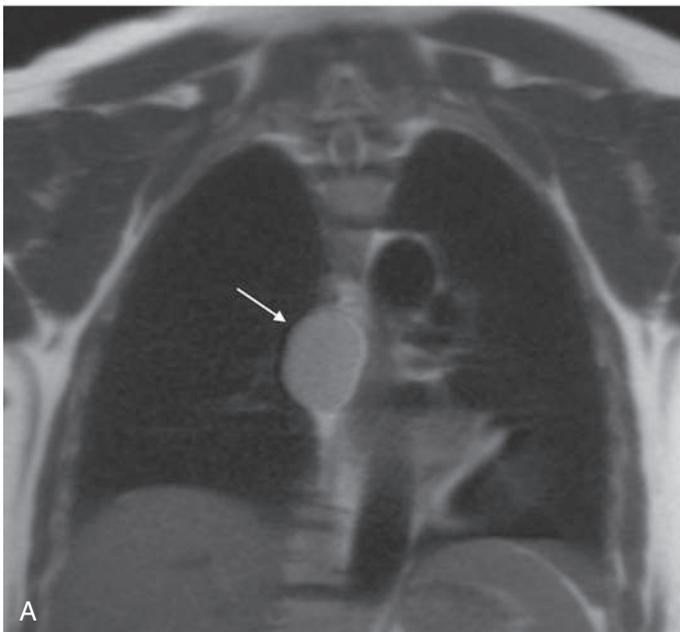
Middle mediastinal mass. Magnetic resonance images demonstrate a subcarinal mass (*arrows*). Coronal HASTE (A) and axial STIR (B) images demonstrate increased T2 signal (appearing gray or white) intensity in this mass, suggestive of a cystic lesion. Subtraction VIBE image (C) shows no enhancement (the mass is black) confirming no contrast enhancement. The diagnosis is a bronchogenic cyst, a benign lesion.
